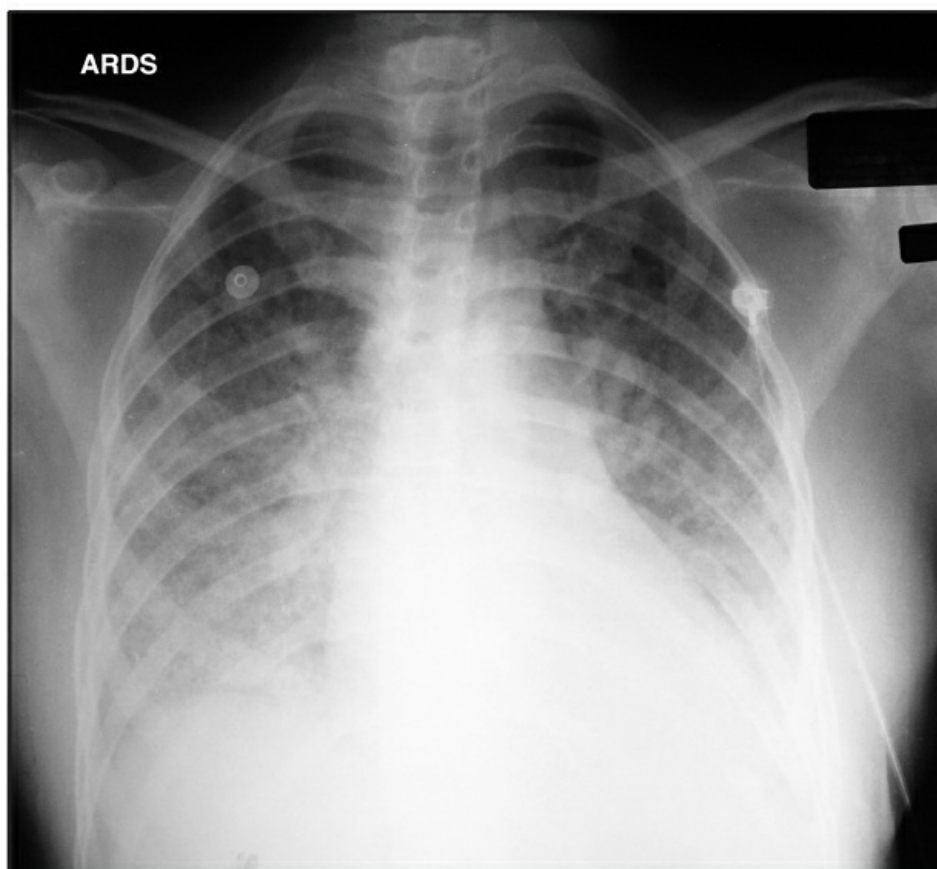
Variable chest x-ray appearance in ARDS. The top panel shows the classic radiographic appearance, with finely granular infiltrates that are evenly distributed throughout both lungs. The bottom panel (which is from a case of ARDS secondary to gram-negative septicemia) shows bilateral infiltrates that are confined to the lower lung fields, with obliteration of the left hemidiaphragm suggesting a pleural effusion.
